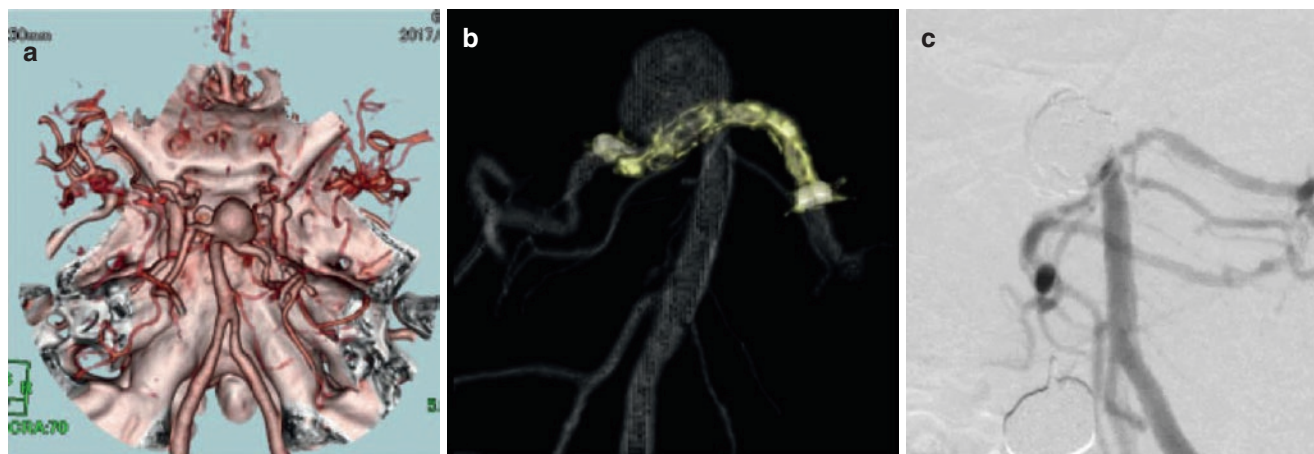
(a) 3D CTA demonstrating a non-ruptured large basilar tip aneurysm associated with Moyamoya disease. The bilateral posterior cerebral arteries (PCAs) are incorporated in the aneurysm. (b) A
